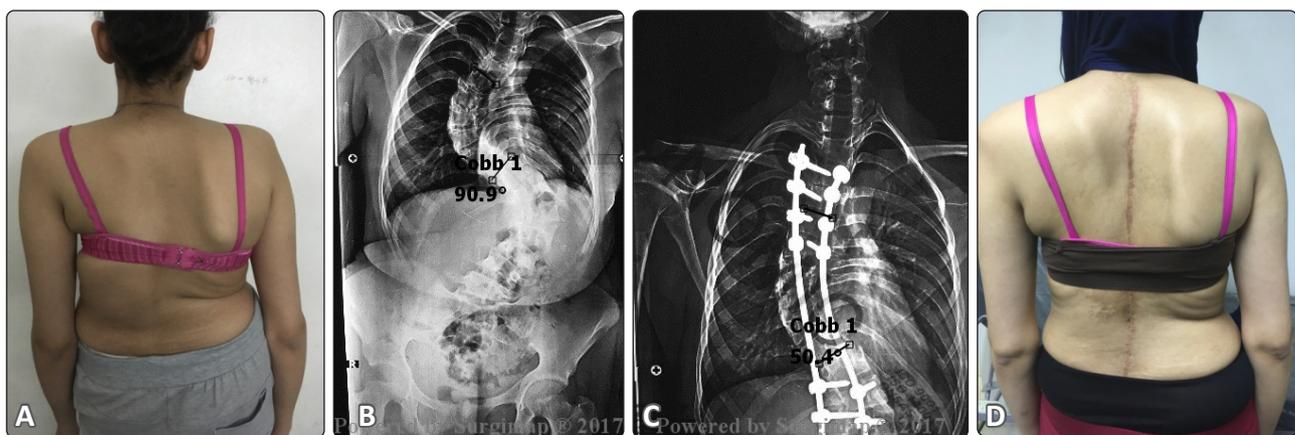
(A) 17-year-old female with RT rib hump and waist line asymmetry. (B) Plain X-ray film of the whole spine showing double major adolescent idiopathic scoliosis with a main thoracic curve to 91 degrees. (C) Postoperative plain X-ray film showing satisfactory correction of the main thoracic curve to 51 degrees via a single posterior operation. (D) Postoperative clinical photo with satisfactory correction waist line asymmetry but with residual rib hump.
